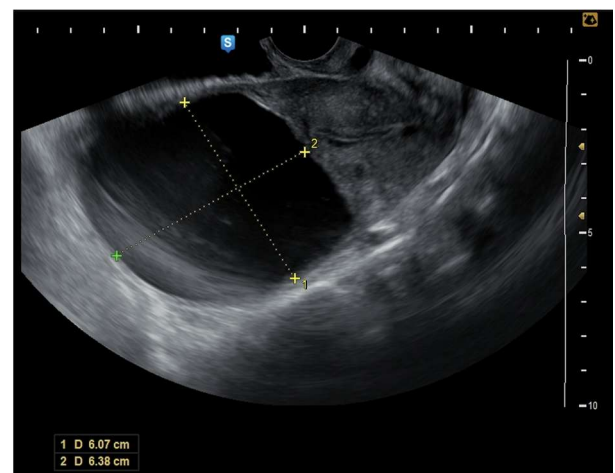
Ultrasound image of a left paratubal cyst.
